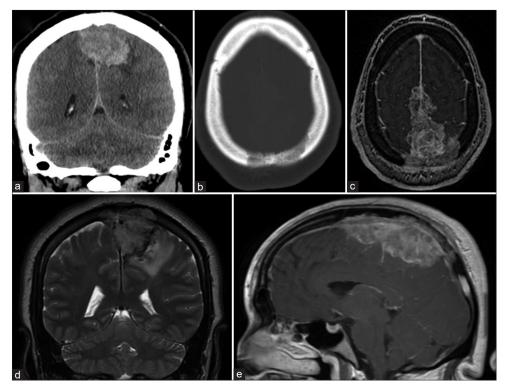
Baseline noncontrast computed tomography and magnetic resonance imaging (MRI) images of the brain. (a) Coronal view shows an interhemispheric mass with left-sided mass effect. (b) Axial view using bone window reveals lytic involvement of calvarium. (c) Axial T2-weighted MRI shows superior sagittal sinus involvement. (d) Coronal T2-weighted MRI reveals tumor extension through the calvarium. (e) Sagittal T1-weighted MRI post-gadolinium shows tumor enhancement.
